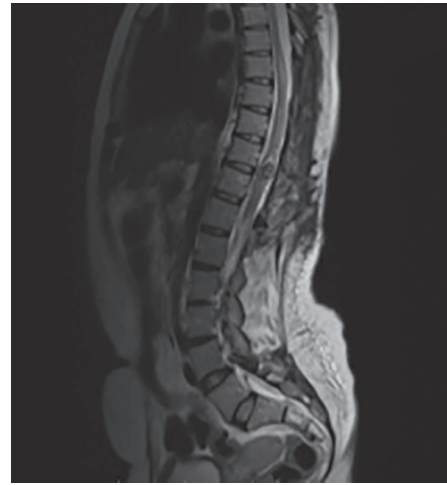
MRI T2 weighted image showing residual AVF and postoperative changes at D10 and D11 levels after 1 year
